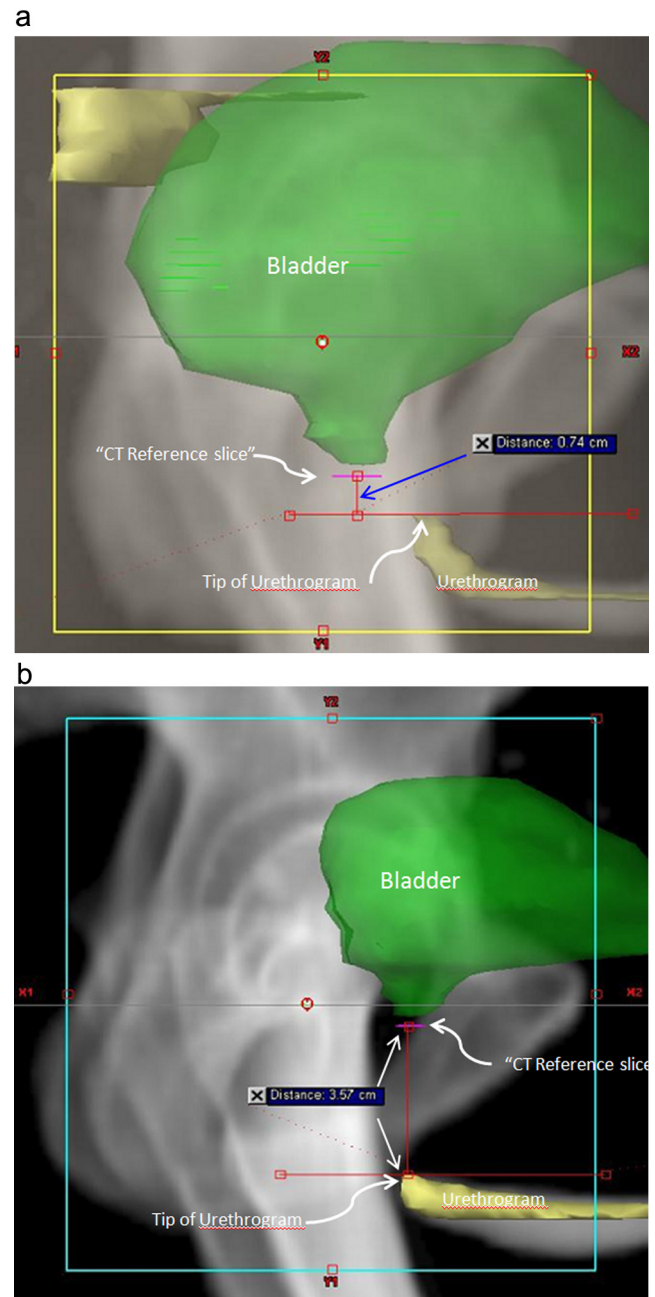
Examples of the range of anatomic variation in the distance between the tip of the urethrogram cone and the Bladder CT Reference Slice. (a) Short anastomosis 7.4 mm; (b) long anastomosis 35.7 mm.
